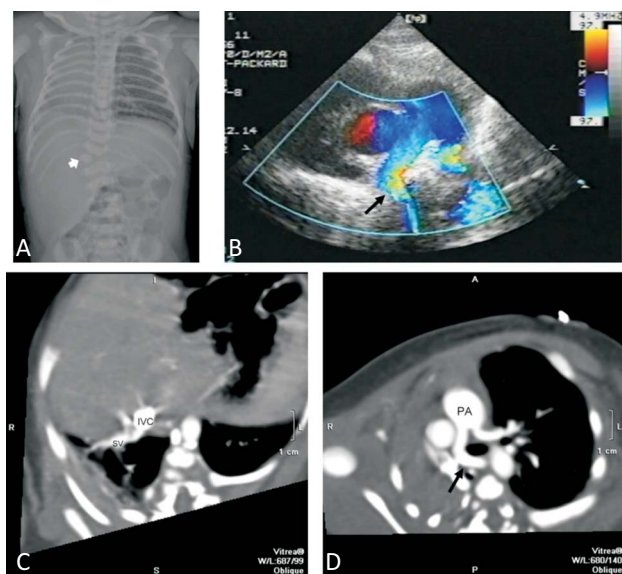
(A) Chest radiograph. (arrow-head: hemivertebra). (B) Echocardiography in parasternal short axis view. (arrows: partial left pulmonary artery sling). (C) Computed tomography: SV (scimitar vein), IVC (inferior vena cava). (D) Computed tomography showed partial left pulmonary artery sling (arrow).
